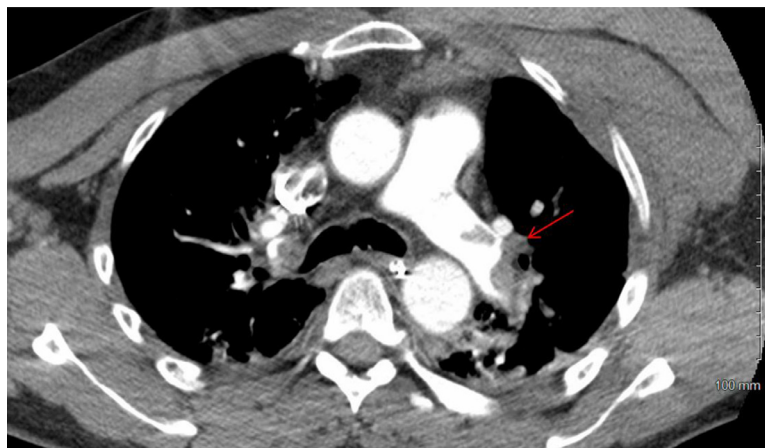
CTA pulmonary (axial view) with thrombus in the left pulmonary artery (red arrow).
